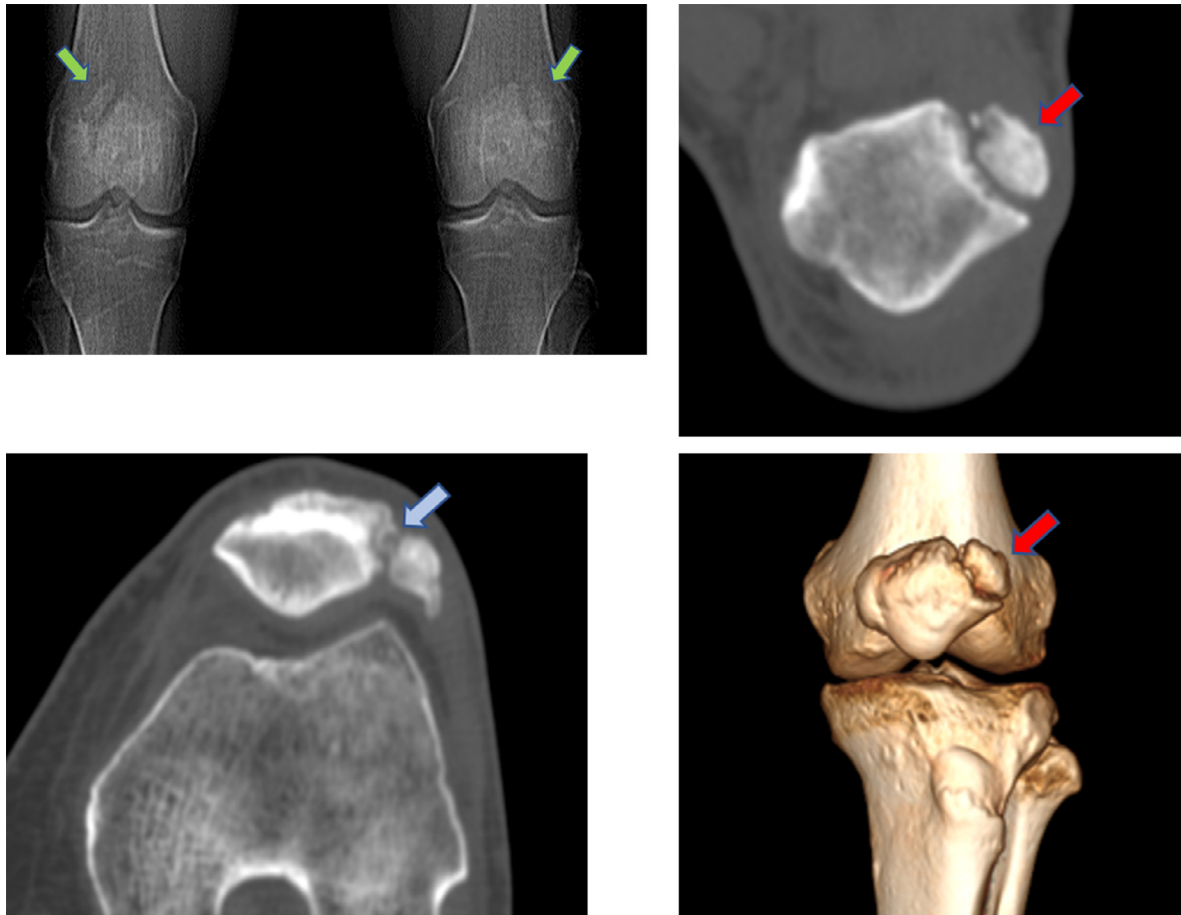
Frontal radiograph of the knees (A) and CT scan of the knees in coronal (B), axial (C), and Volume Rendering (D) reconstructions showing an appearance of the bilateral bipartite patella (green arrows) of interest in the superior-external portion (red arrows), with the irregular appearance of the synchondrosis (light blue arrow).
